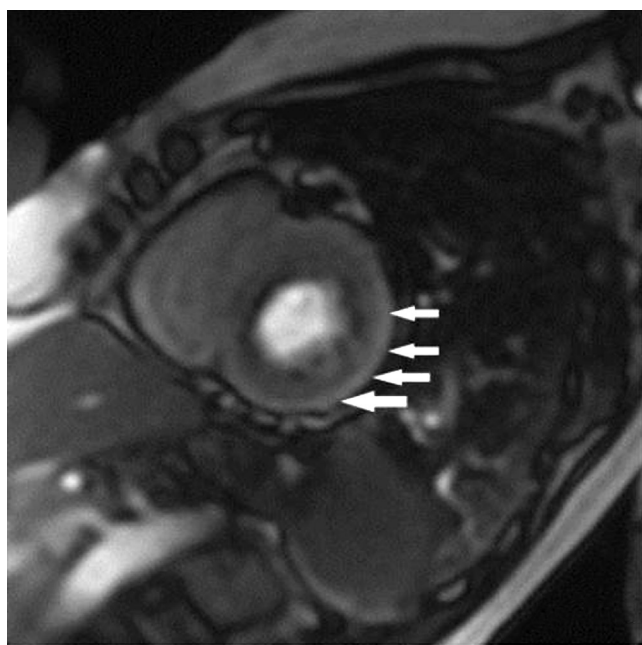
Cardiac MRI in TI gradient echo/echo planar imaging pulse sequence showing a diffuse subendocardial perfusion defect in the left ventricle wall of an SSc patient. Adapted from Rodrigues-Reyna et al. [124].
